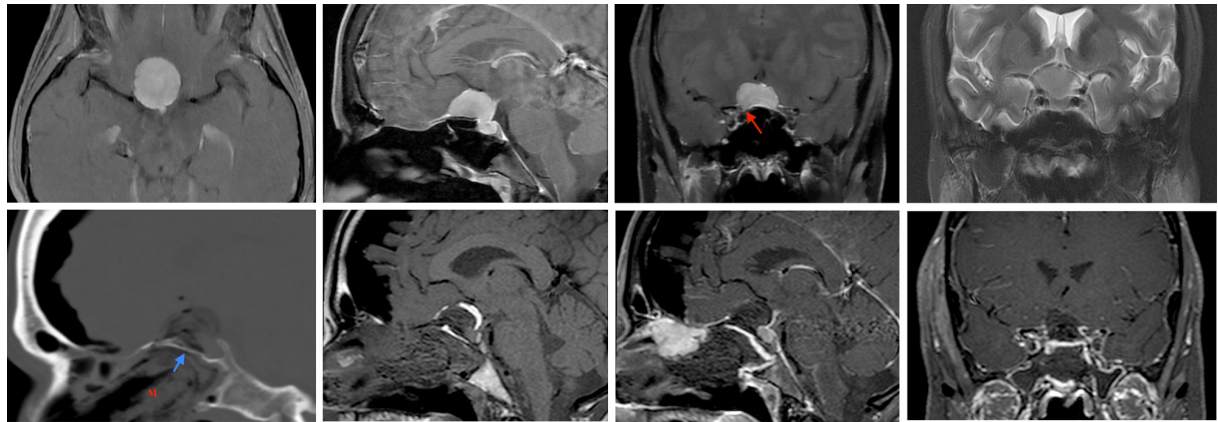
A 52-year-old woman presented with progressive bilateral vision loss, right worse than left, over three years. (Top row) Pre-operative imaging demonstrates a large tuberculum sellae/posterior planum meningioma with extension into the sella. Bilateral optic canal invasion is seen, right more than left (red arrow). There is no supraclinoid carotid artery encasement, or lateral extension. The pituitary infundibulum is displaced posteriorly. An endoscopic transtuberculum/transplanum approach was performed. (Bottom row) Post-operative imaging shows gross total resection. Sagittal CT and MRI demonstrates nasal packing up ("M") to the bony buttress (posterior nasal septum graft; blue arrow) with fat graft and collagen sponge in the resection cavity and a well-vascularized nasoseptal flap is in place with pituitary gland and infundibulum enhancing normal. Within 2 weeks of surgery her visual field deficit resolved, and visual acuity remained stable. See Video 1.
